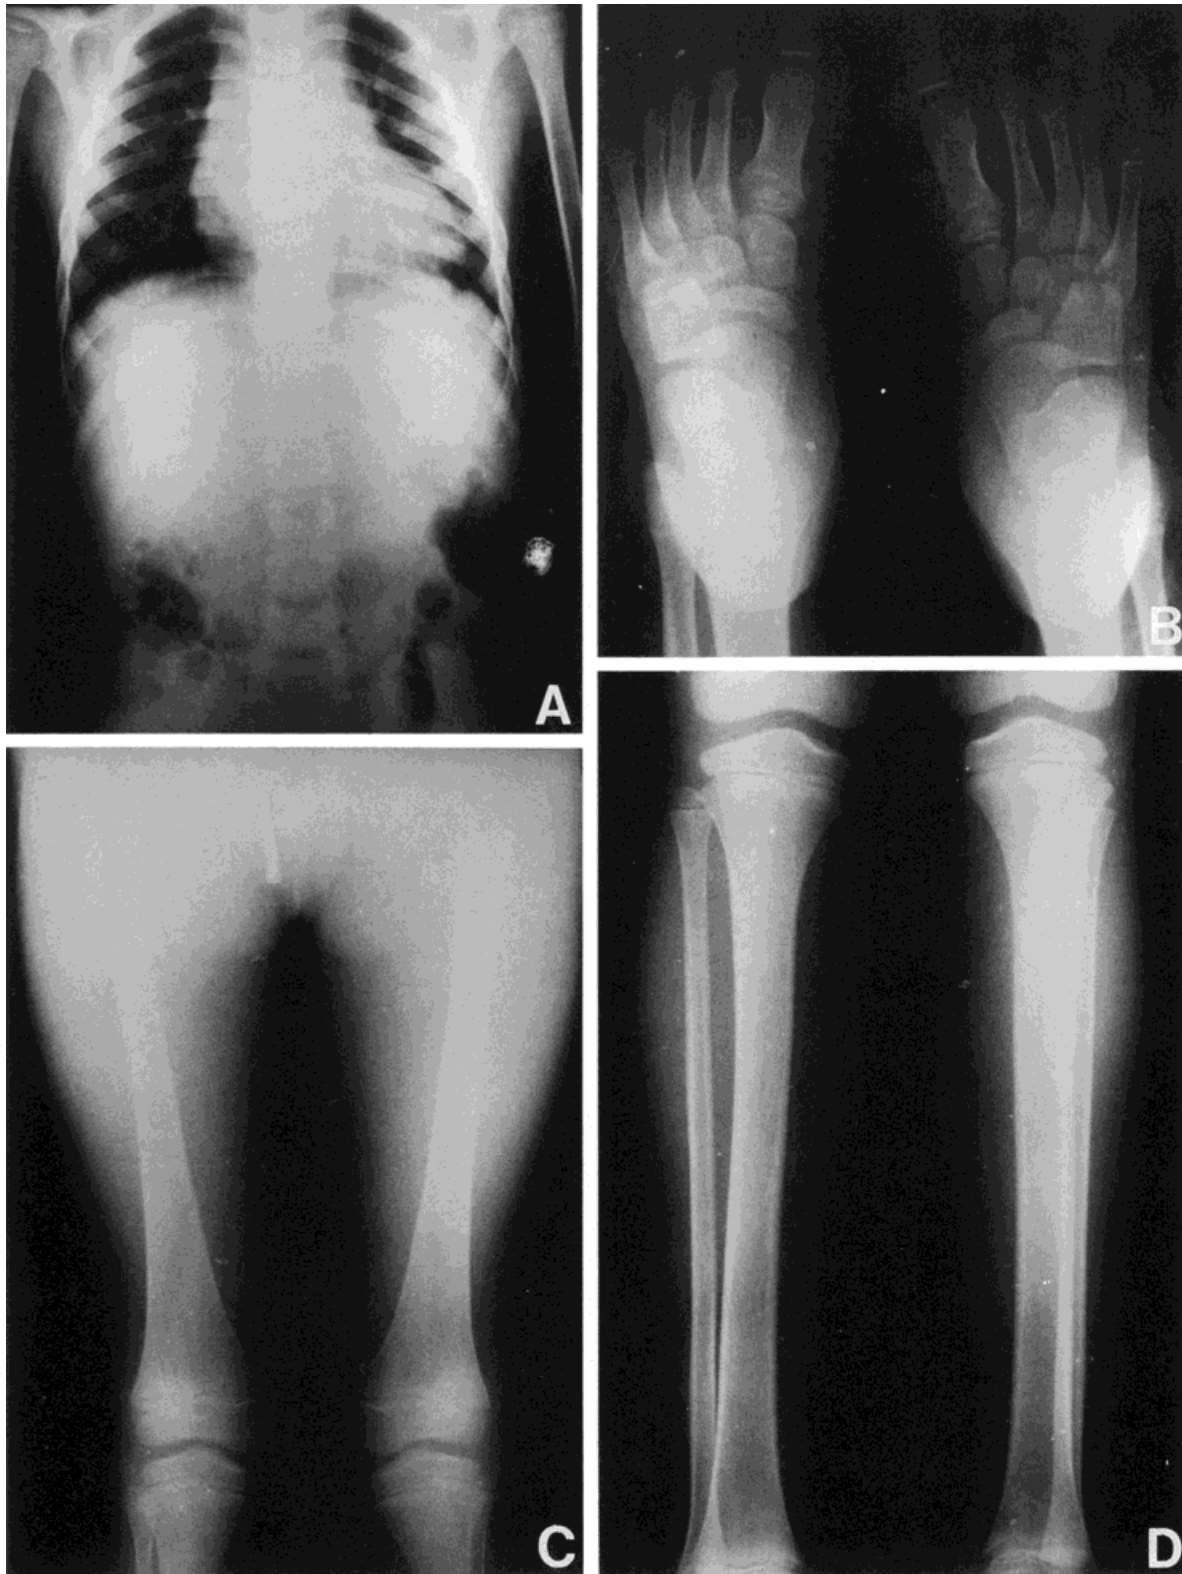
Patient A, X-rays at age 8 years. Note: (A) Global cardiomegaly, (B) broad first metatarsal, with short and broad distal phalanx, and (C and D) broad metaphyses and medullary canals of the long bones.
